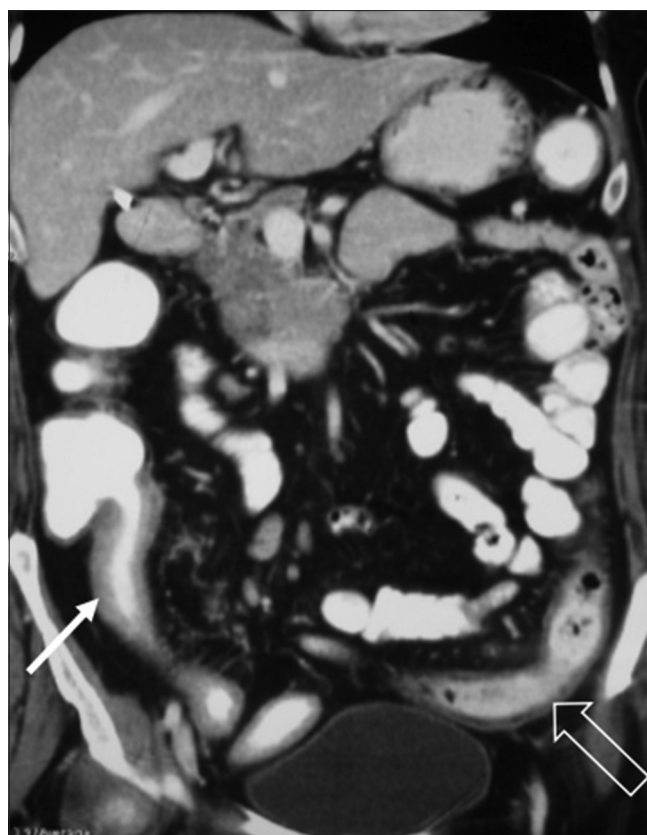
Conventional CT (coronal reformat) using positive oral contrast shows long-segment thickening (arrow) in the terminal ileum without cecal involvement and another noncontiguous ileal segment showing wall thickening (outlined arrow) suggestive of Crohn's disease
